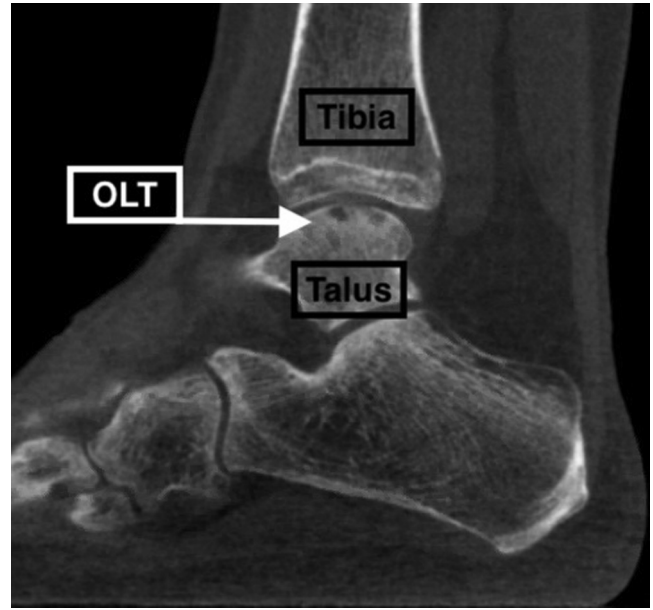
Sagittal computed tomography scan view of left ankle showing osteochondral lesion of lateral talus (OLT).
